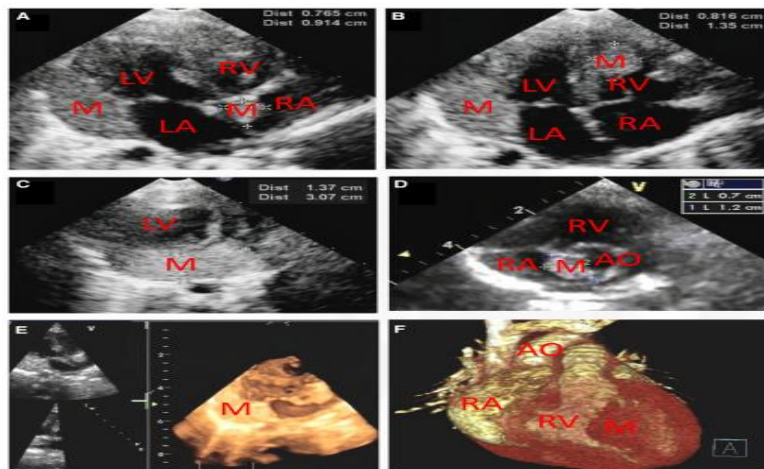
Transthoracic echocardiography (A–D), Three dimensional echocardiography (E) and Three-dimensional cardiac computed tomography angiography (F)
